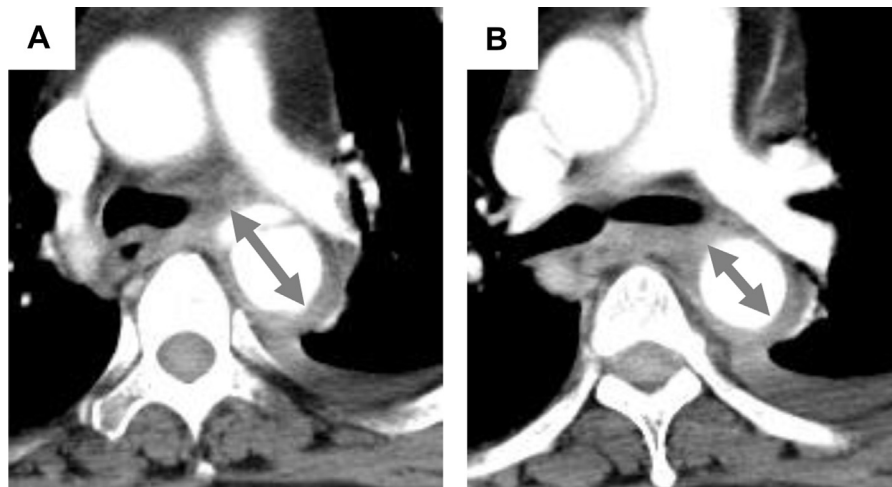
Radiographic findings included (A) pseudoaneurysm maximal width and (B) normal aortic diameter (*double arrowhead*).
